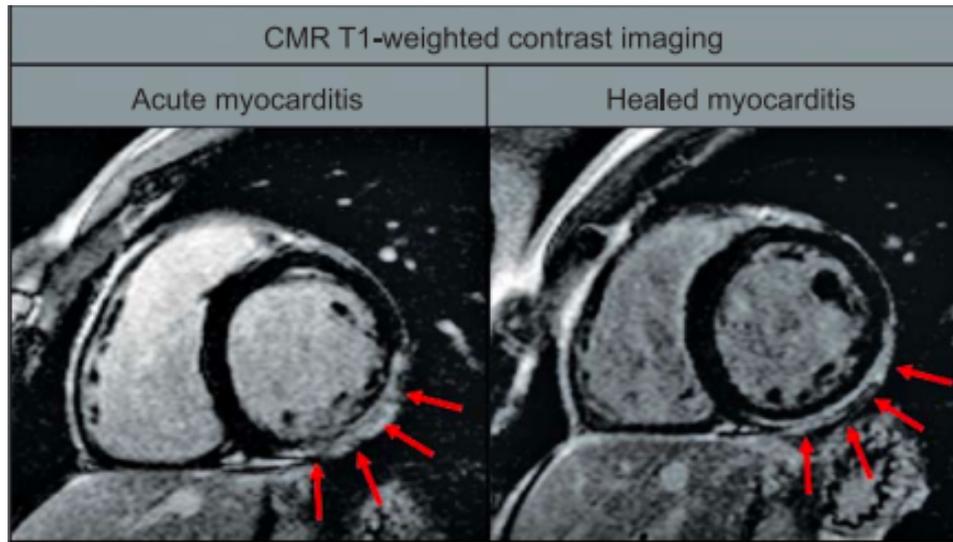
Cardiac magnetic resonance image of a patient with myocarditis using LGE techniques.
